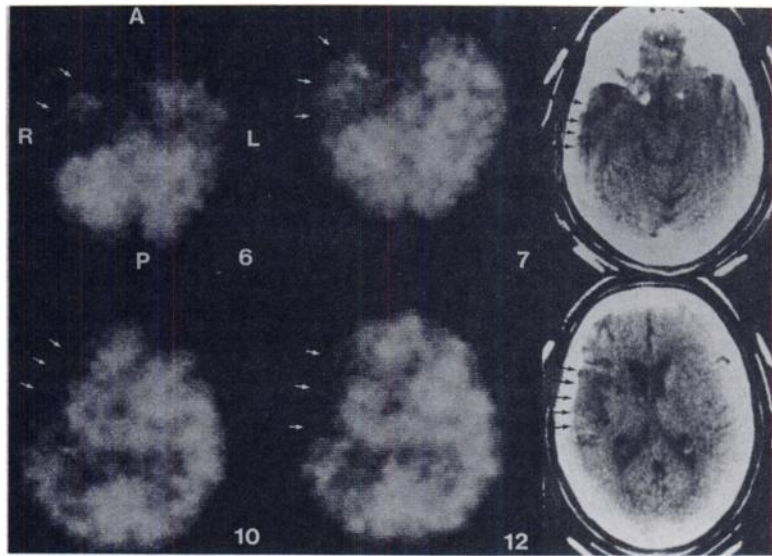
SPECT and TCT examination of 53-yr-old female with right-sided occlusion of internal carotid artery. Four transverse SPECT sections at left were obtained with *N*-isopropyl-*p*-[¹²³I]iodoamphetamine, and demonstrate reduced blood flow to right temporal and parietal lobes (arrows). Dose administered was 5 mCi (185 MBq) and acquisition time was 30 sec for each of 64 angles using LEAP collimator. RR = 14 cm. At right are two corresponding TCT scans to demonstrate infarction in same regions (arrows).
